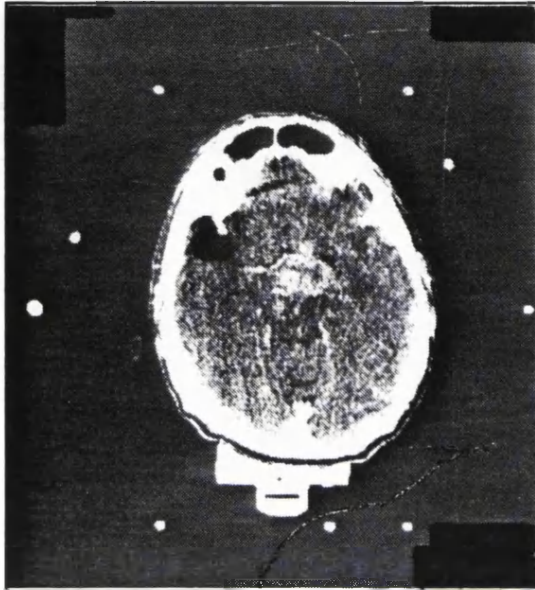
Case 9: CT scan showing biopsy target
